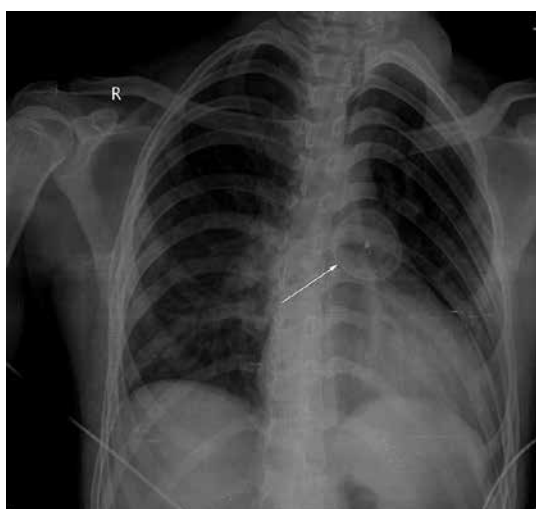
Chest X-ray view of our 3rd patient showing the embolized device in the pulmonary conus
